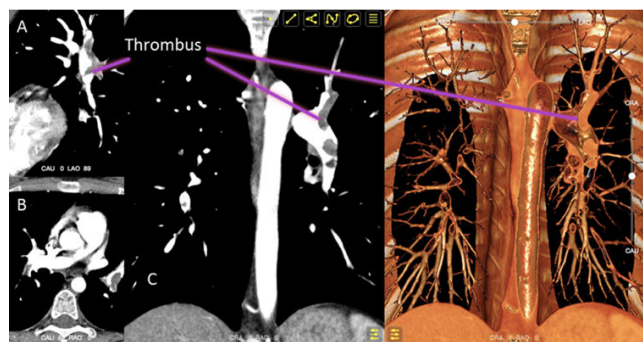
Contrast CT angiography. A. Sagittal plane; B. Transverse plane; C. Frontal plane. Embolus in the main right pulmonary artery extending to the both lobar arteries and below.
